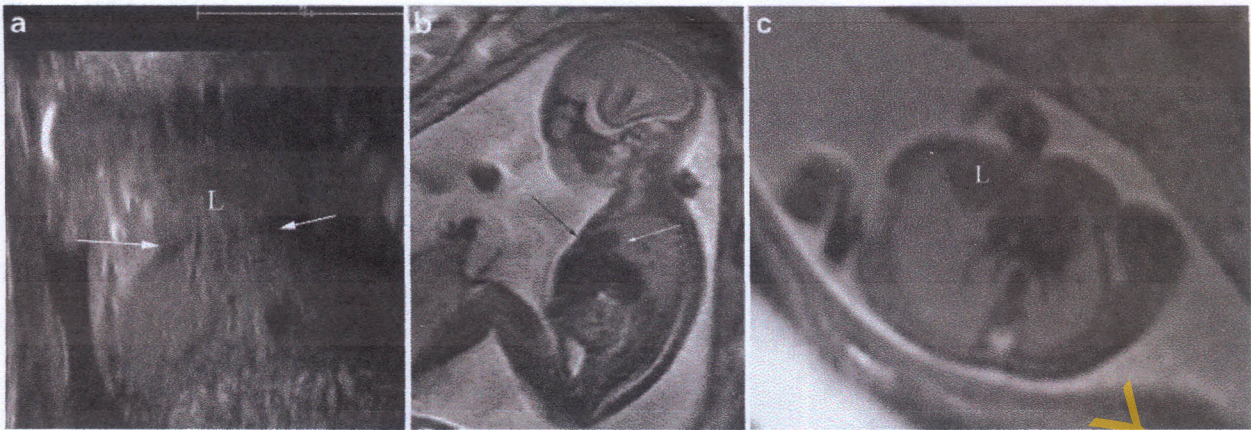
Morgagni hernia in a 20-week fetus. a Sagittal sonogram through the right fetal chest shows herniation of the liver (*L*) into the chest; *arrows* depict the hernia. b, c Sagittal (b) and axial (c) T2-W
